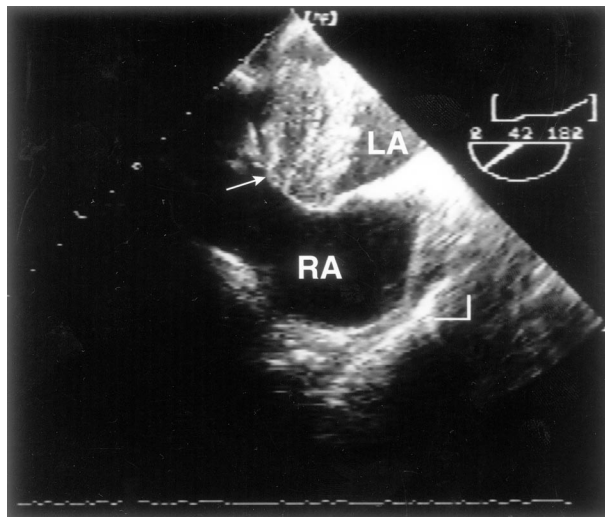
Transesophageal echocardiogram depicting the 0.5-cm stalk of the left atrial myxoma originating from the fossa ovalis (white arrow).
